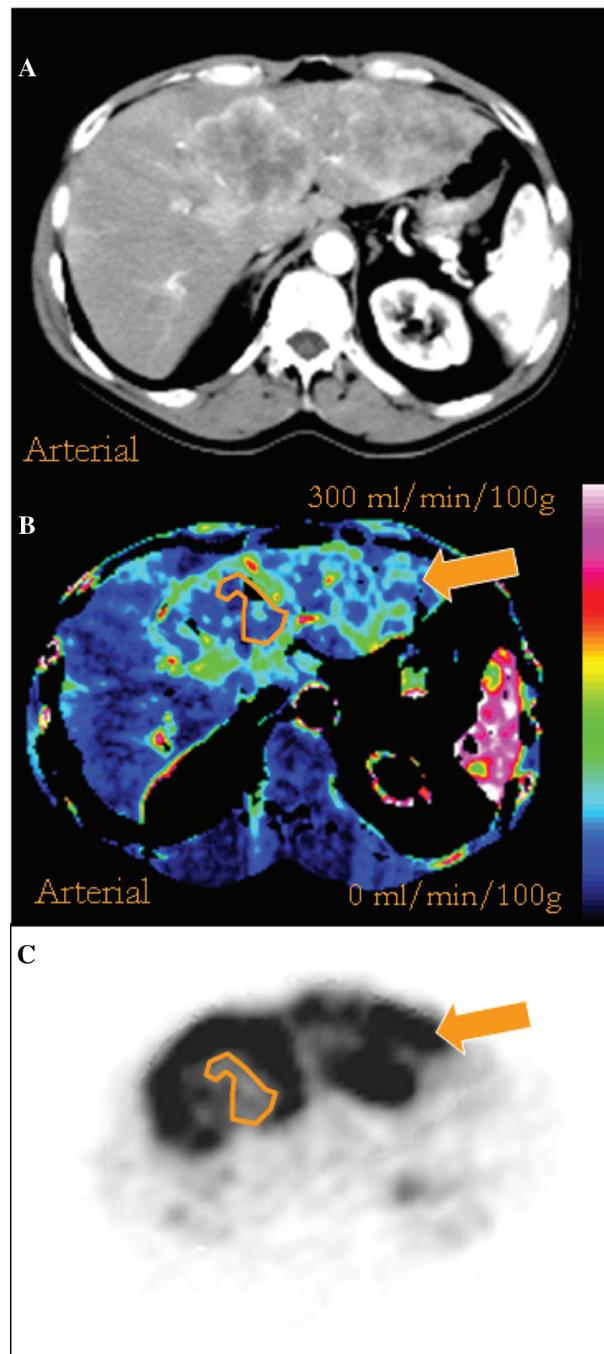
Conventional contrast-enhanced CT (A), perfusion CT (B) and FDG-PET (C) images of a large hepatic metastasis from colorectal cancer demonstrating regional areas of mismatch between vascularity and metabolism. The orange polygon outlines an area of tumour necrosis with markedly reduced vascularity and metabolism. Regions of reduced vascularity but increased FDG uptake can be seen adjacent to the necrotic zone and in the left lobe of the liver (arrow).
